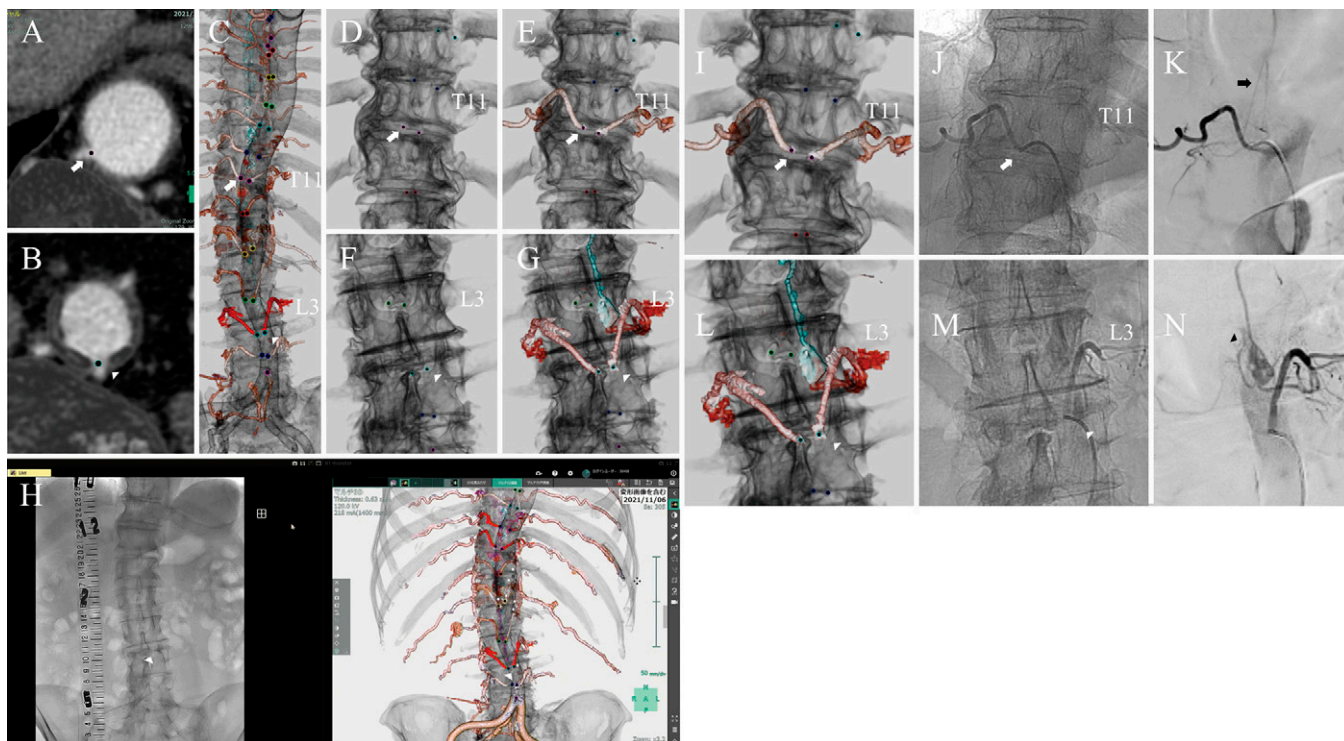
Preoperative preparation using CTA and sDSA images in representative segmental arteries. *White arrows* indicate the bifurcation of the right T11 segmental artery; *white arrowheads*, the left L3 segmental artery; *black arrow*, artery of Adamkiewicz; *black arrowhead*, epidural arteriovenous fistula. The bifurcation of the segmental arteries from the aorta is marked on axial CTA images (A and B). C: The markers for bifurcations are merged with vascular and spine images. The markers and segmental arteries are shown in different colors. D and E: The pointed bifurcation and structure of the right T11 radicular artery are fused with the vertebral structures. F and G: The feeder and drainer of the spinal epidural arteriovenous fistula were reconstructed and fused, respectively. The same method was applied to all segmental arteries. Fusion and intraprocedural images. H: The sDSA was performed, referring to the fusion image. I–K: The intraprocedural and fusion images were shown on the screen. sDSA shows canulation and angiography of the right T11 segmental artery. The right T11 segmental artery was selected based on the fusion image and the bony structure. The artery of Adamkiewicz branches from the right T11 radicular artery. L–N: sDSA showing canulation and angiography of the left L3 segmental artery. The left L3 segmental artery was selected based on the fusion image. An epidural spinal arteriovenous fistula was also identified. The same method was applied to all segmental arteries.
